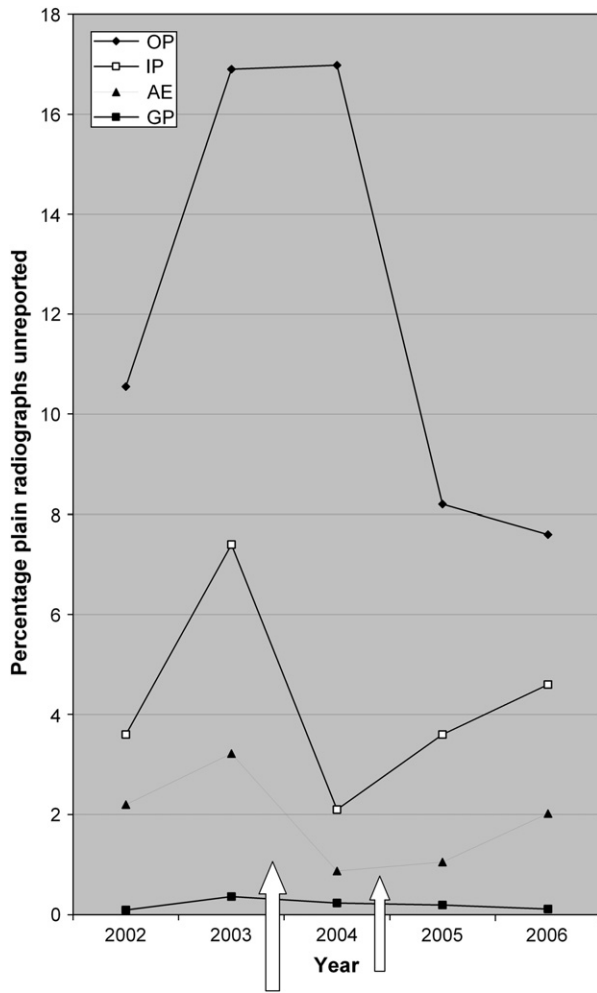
Percentage plain radiographs unreported per month 2002–2006.
